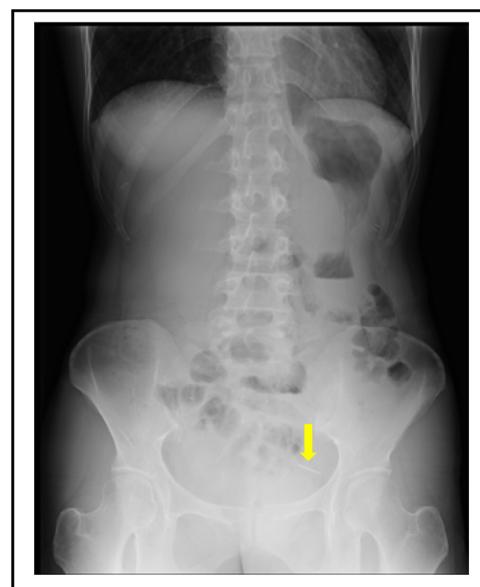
Abdomen X-ray one year ago shown the same shape and size of the radiopaque object located at the left lower abdomen, which suggested the firm fixation of the needle to the abdominal wall.
